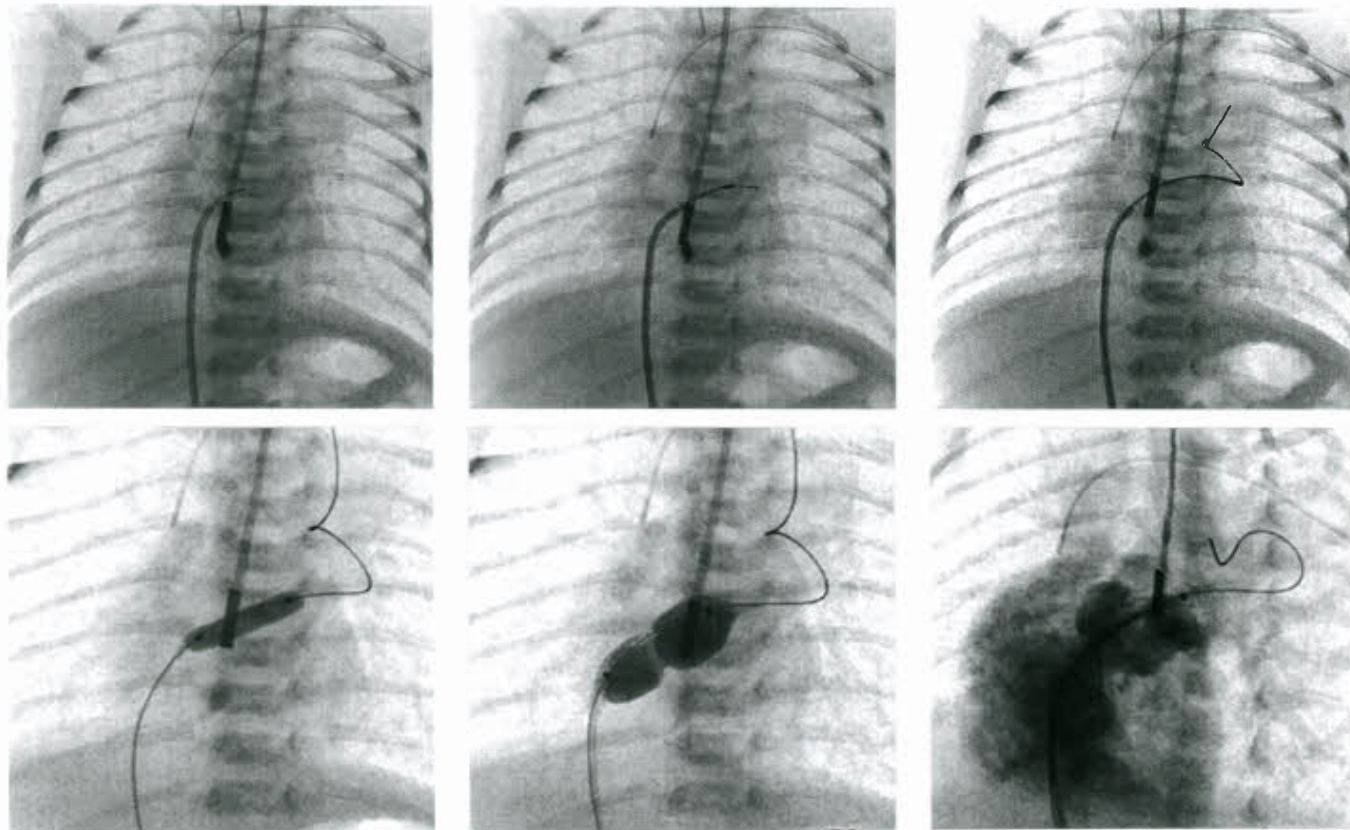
Septoplasty. RF perforation of the atrial septum followed by cutting and standard atrial balloon septoplasty in a 7-day-old infant with hypoplastic left heart syndrome, intact atrial septum, and a restrictive decompressing vein. Images (from left to right and top to bottom) demonstrate the RF wire across the atrial septum, the coaxial catheter advanced over the RF wire into the LA, and wire position through the coaxial catheter into the decompressing vein. Cutting balloon septoplasty is followed by standard balloon atrial septoplasty and final left atrial angiography demonstrating the newly created intra-atrial communication. An intracardiac echocardiographic probe is utilized in TEE position.
